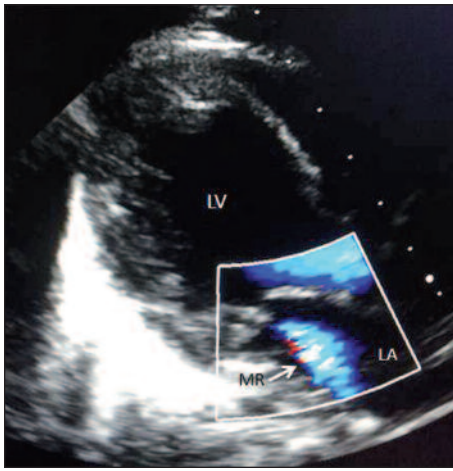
Mitral valve regurgitation is observed in echocardiographic examination.
